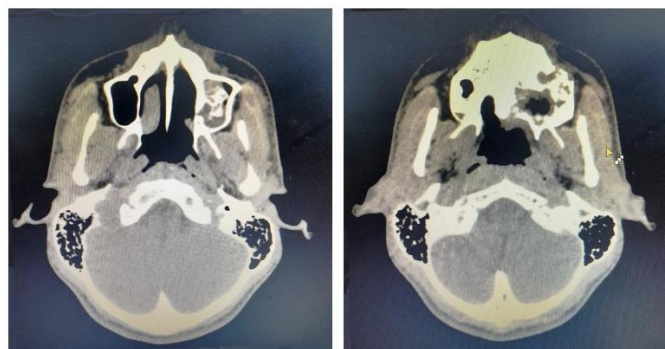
Maxillary axial CT scan at two different levels revealing an expansile destructive mass in the left side.
